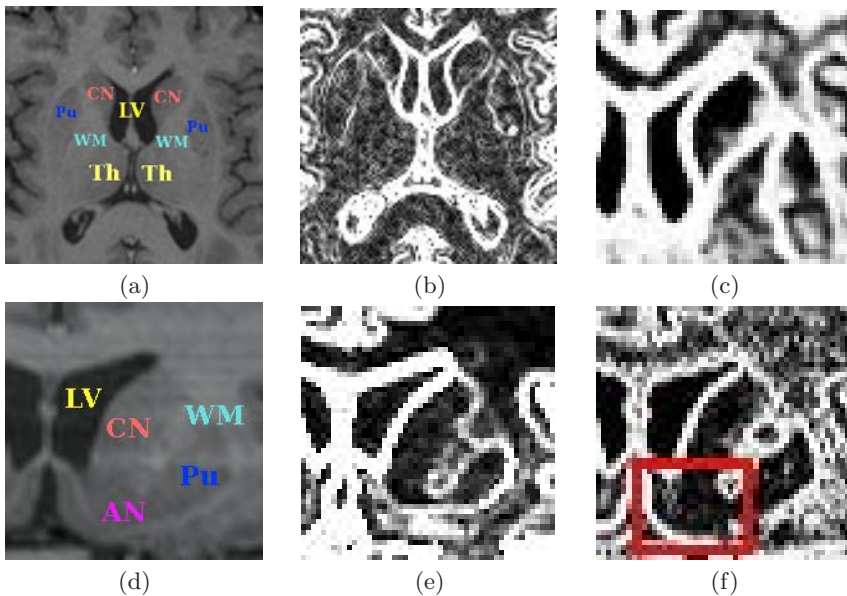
(a) One axial slice of a brain MRI volume. (b) $\|\nabla I\|$. (c) $g(\|\nabla(p_{CN}(I))\|)$ on an axial view. (d-f) Coronal views.
